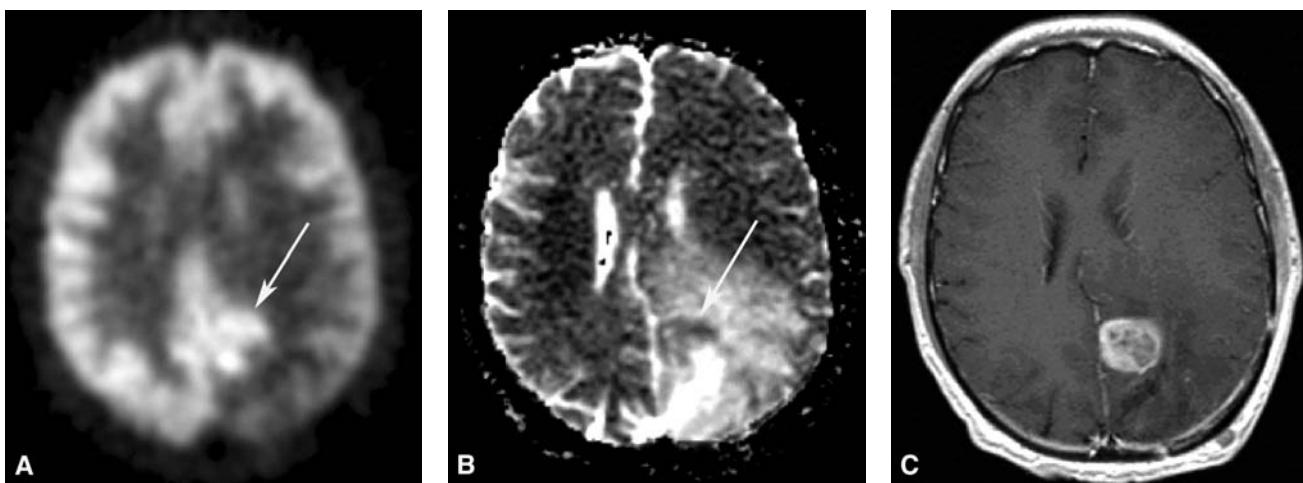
A 49-year-old man with an anaplastic astrocytoma. The PET scan (A) demonstrates a C-shaped area of increased radiopharmaceutical uptake, which exquisitely matches the area of restricted diffusion on the ADC map (B). The correspondence between the FDG-PET scan and the ADC map is better than the gadolinium-enhanced MRI (C). Abbreviations: ADC, apparent diffusion coefficient; PET, positron emission tomography; FDG-PET, 2-fluoro-2-deoxy-D-glucose positron emission tomography.
